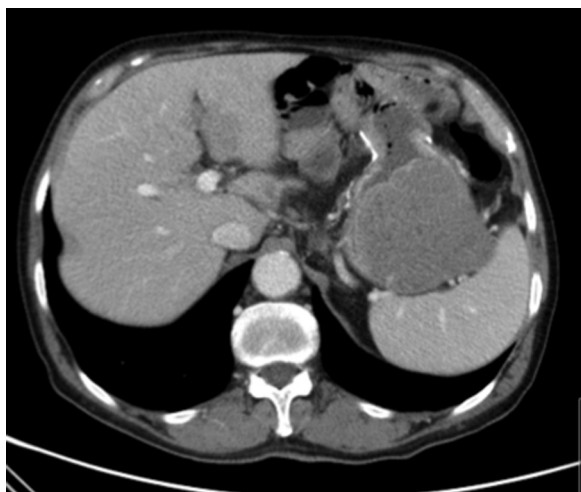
CT-imaging showing the hepatic and gastric masses.
